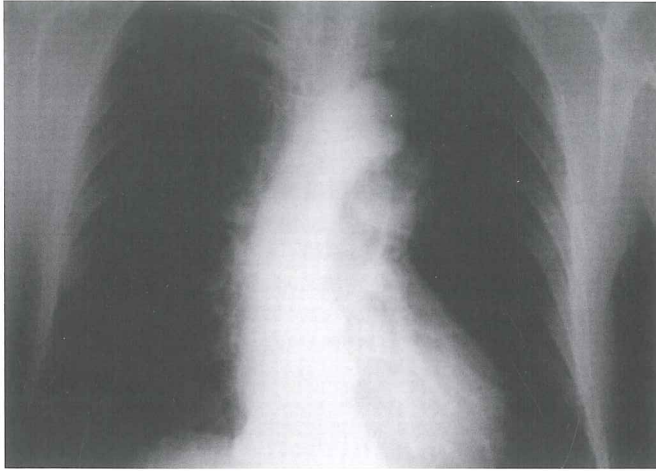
X-ray and computed tomographic scan of chest show cystic mass at anterior mediastinum
